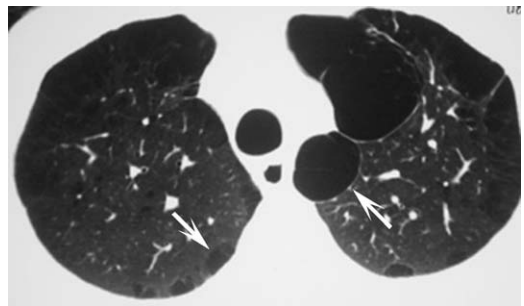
HRCT assessment of emphysema: distal acinar and paraseptal emphysema. Axial HRCT image through the upper lobes shows subpleural areas of low attenuation with very thin, uniform walls (*arrows*) consistent with paraseptal emphysema. Note how paraseptal emphysema forms a single layer in the subpleural regions of lung.
